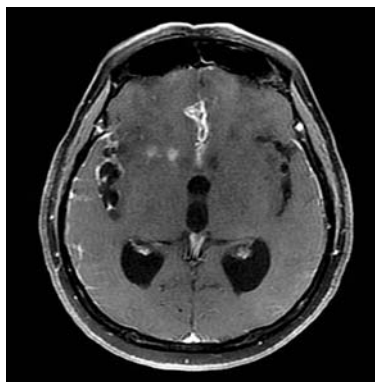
Contrasted T1-weighted image showing inflammation with contrast enhancement.
